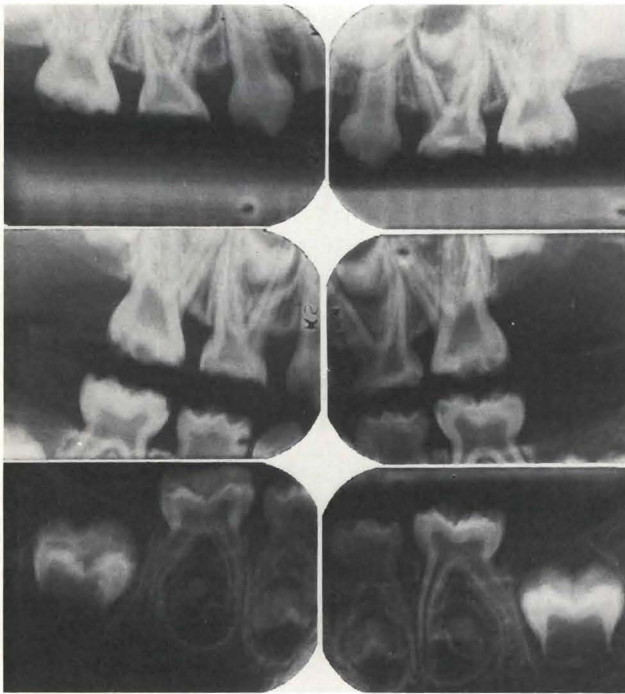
Intraoral radiographs exhibiting generalized enamel hypoplasia.
